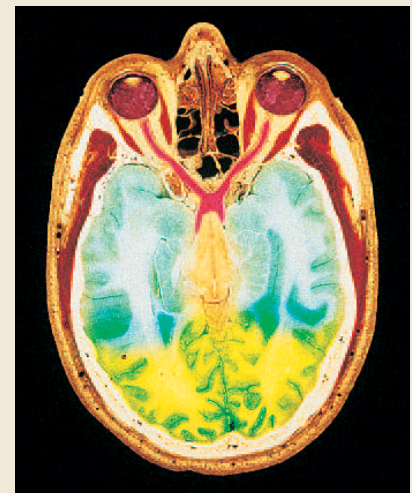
Figure C Computed Tomography
